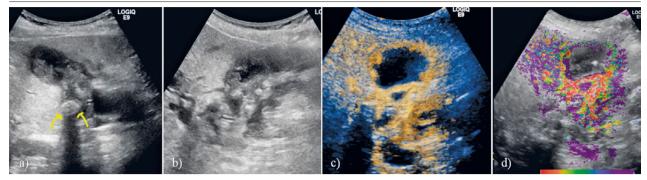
Severe acute cholecystitis (gangrenous cholecystitis). Ultrasonographic exploration in grayscale (a,b) (perpendicular sections; gallbladder lumen filled with cellular debris; in the fundic region – arrow – presence of a stone image); CEUS exploration in arterial phase (c) (uneven and irregular loading of the walls observed). Parametric analysis of angioperfusional behavior in arterial phase (d).
